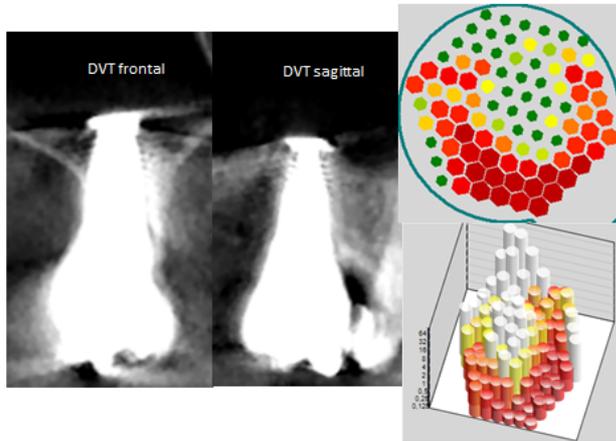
Left and mid window show DVT/CBCT frontal and sagittal images of implant 16 without any conspicuous signs of inflammation. Right upper 2D-CAVITAU image displays in green apical part of implant (green = hard substance), surrounded by red signs of suspected osteolysis or osteonecrosis (red = low bone density). Right lower 3D-CAVITAU image displays in white hard substance of implant, surrounded by red signs of suspected osteolysis or osteonecrosis.
